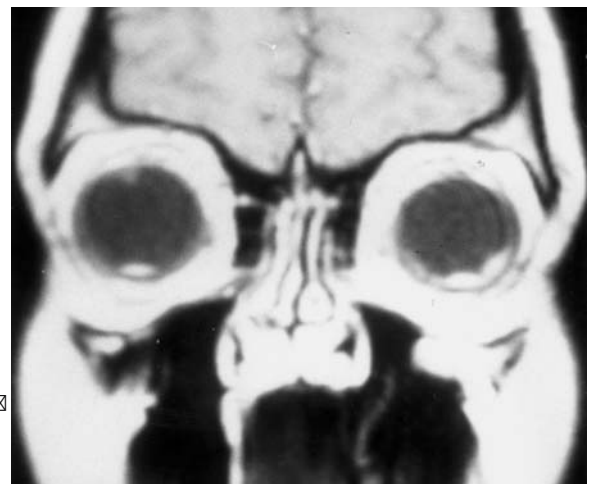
A 20-year-old woman with Hippel-Lindau disease. Diagnosis: bilateral inferior choroidal hemangioma. Coronal T1-weighted MRI. (With permission of Radiologen am Brand, Mainz)
